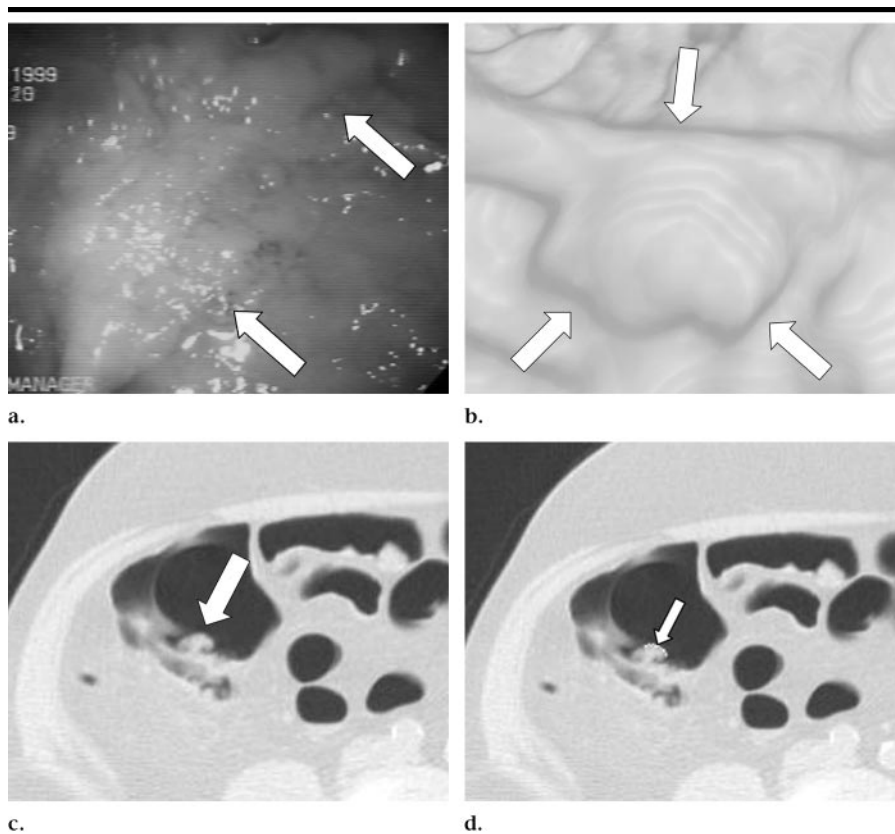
Images of a flat, sessile, tubular 2-cm adenoma (arrows) with high-grade dysplasia that was detected in the cecum of a 75-year-old man with our CAD algorithm but not by either radiologist. (a) Image from conventional colonoscopy. (b) Perspective endoluminal CT colonographic image. The raised portion of the mass is visible. (c, d) Transverse CT colonographic images obtained with the patient in the supine position (c) without and (d) with automated detection marks. In d, an automated detection mark (small white line on edge of mass) identifies one portion of the polyp. A substantial amount of retained solid stool can be observed.
